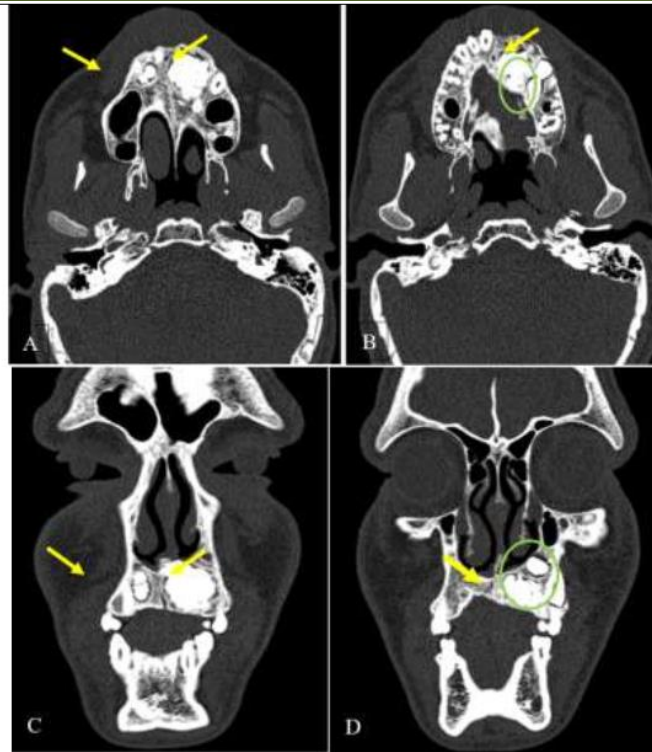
Axial images (A, B) and coronal images (C, D) of facial CT showed a conglomerate and radiopaque, shapeless maxillary masses, surrounding by a well-defined radiolucent rim (yellow arrows) along with impacted retained left teeth (green circle)
